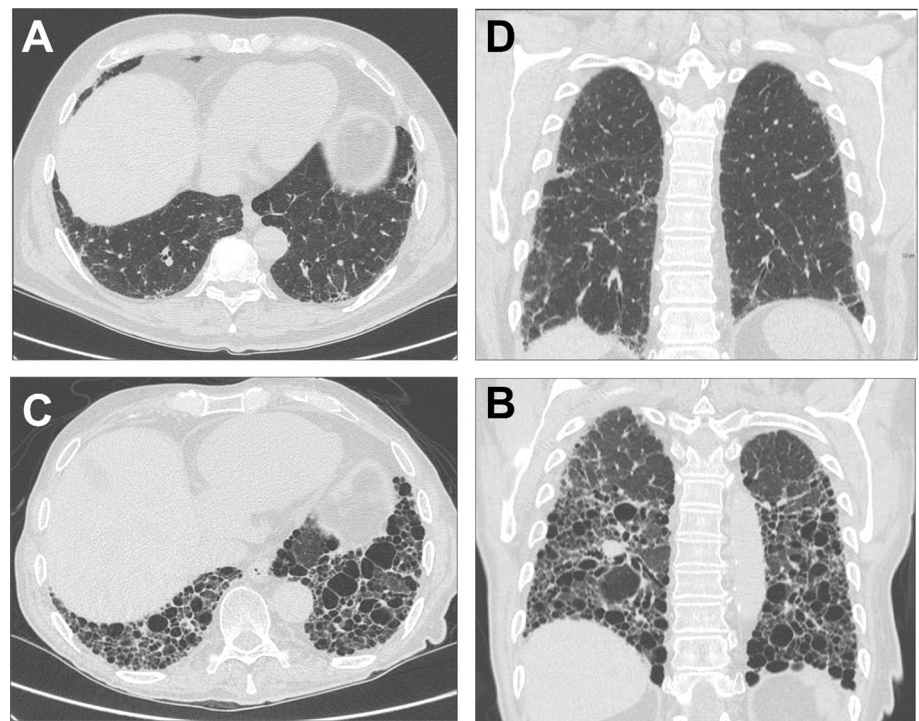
A 69-year-old man with rheumatoid arthritis. Axial (A) and coronal (B) chest HRCT images obtained at the time of diagnosis show small subpleural band-like opacities and mild reticulations in the mid-lower lobes, with a circumscribed cluster of honeycombing in the left lower lobe (UIP pattern); CT images at the same level obtained 4 years later C and D show dramatic progression of fibrotic parenchymal abnormalities with florid honeycombing affecting more than 70% of the fibrotic areas classifiable as 'exuberant honeycombing', evolution compatible with progressive pulmonary fibrosis (PPF) phenotype
